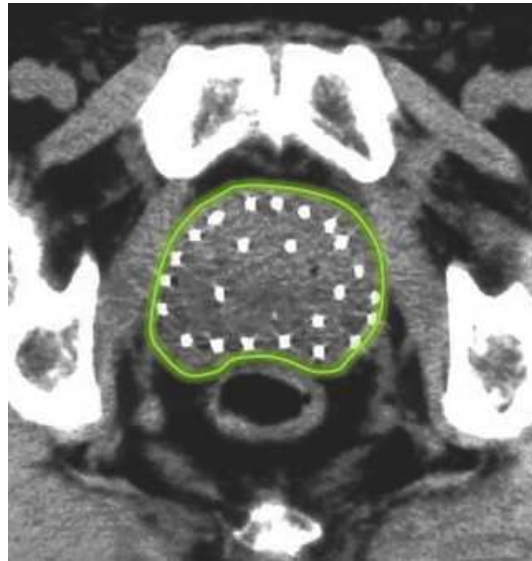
In CT imaging, the soft tissue contrast is poor. However the modality is useful in detecting radioactive seeds as observed in this figure.
